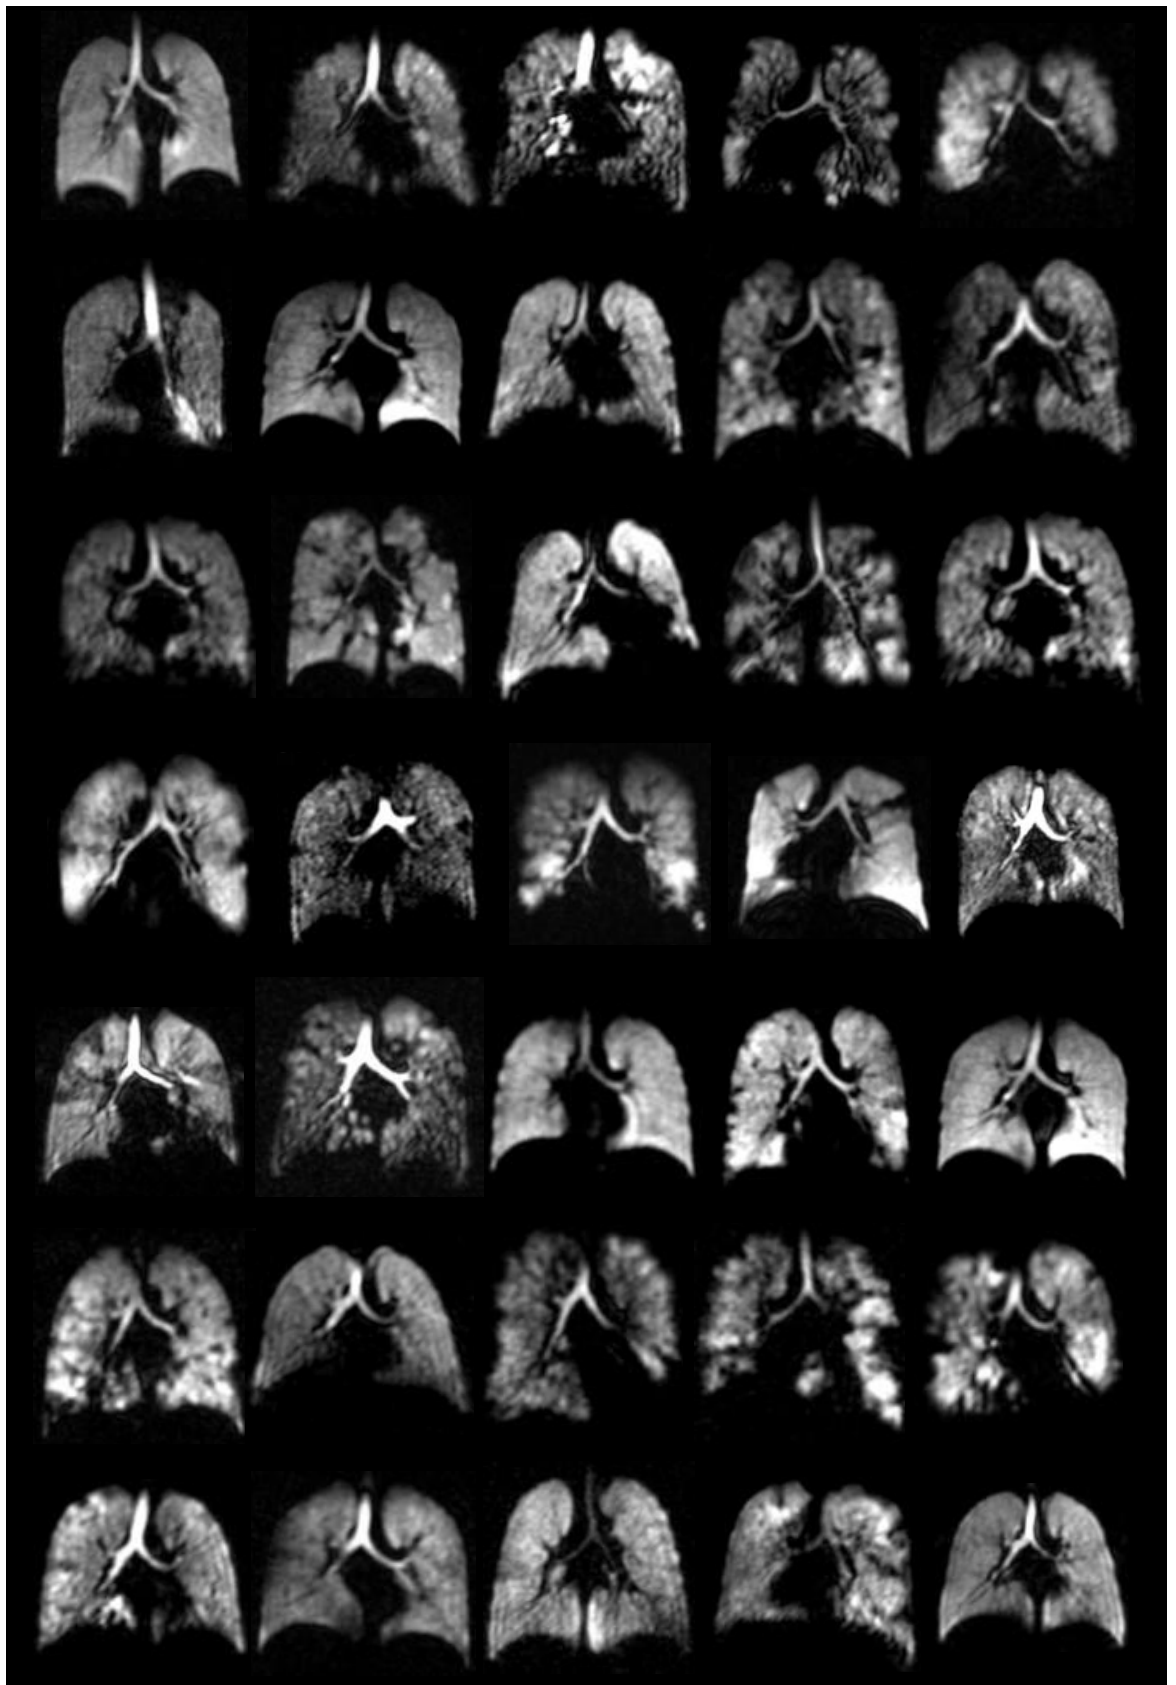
^{129}Xe Ventilation MRI for all participants in the study. Each image depicts a different participant, showing a central slice from their ^{129}Xe Ventilation MRI. Images within this figure have been reduced in size to allow visual comparison between cases.
